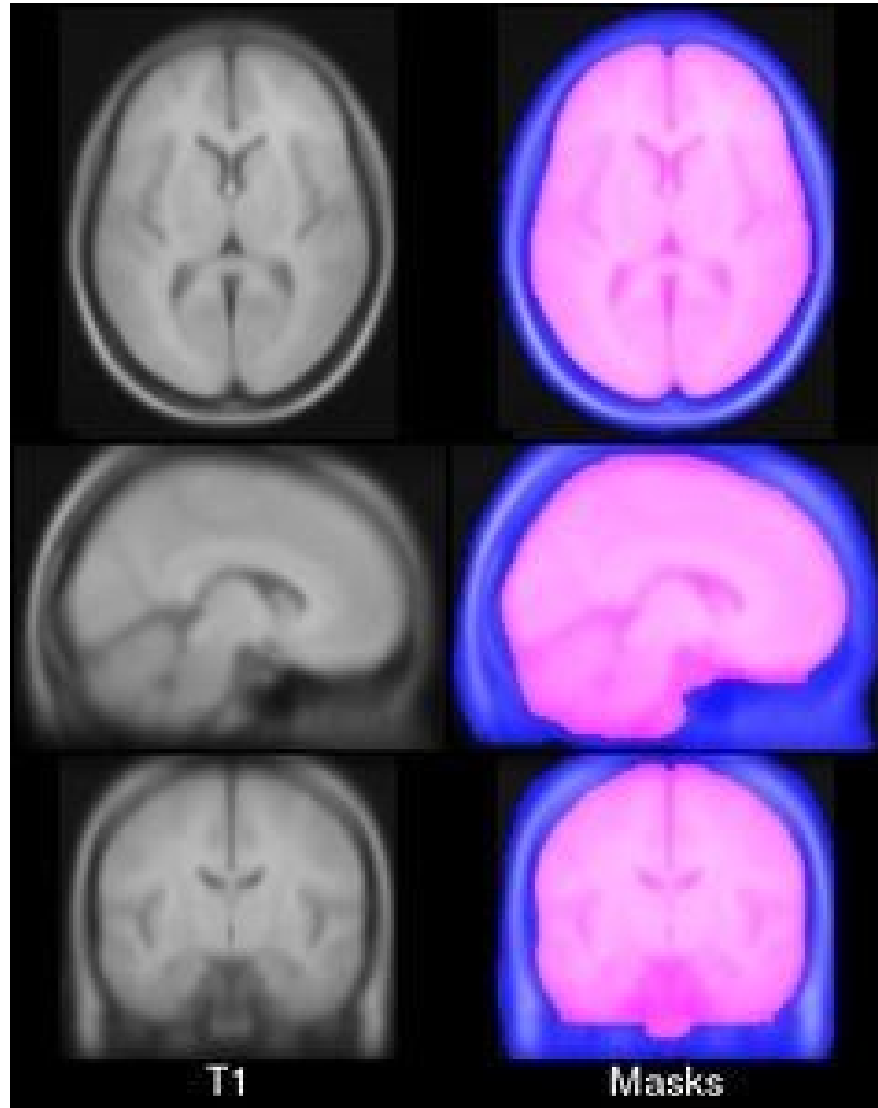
The MNI305 atlas [160]. Left figures are the intensity-averaged MRI scans and right figures are the masks based on segmentation of brain tissue and non-brain tissue.
